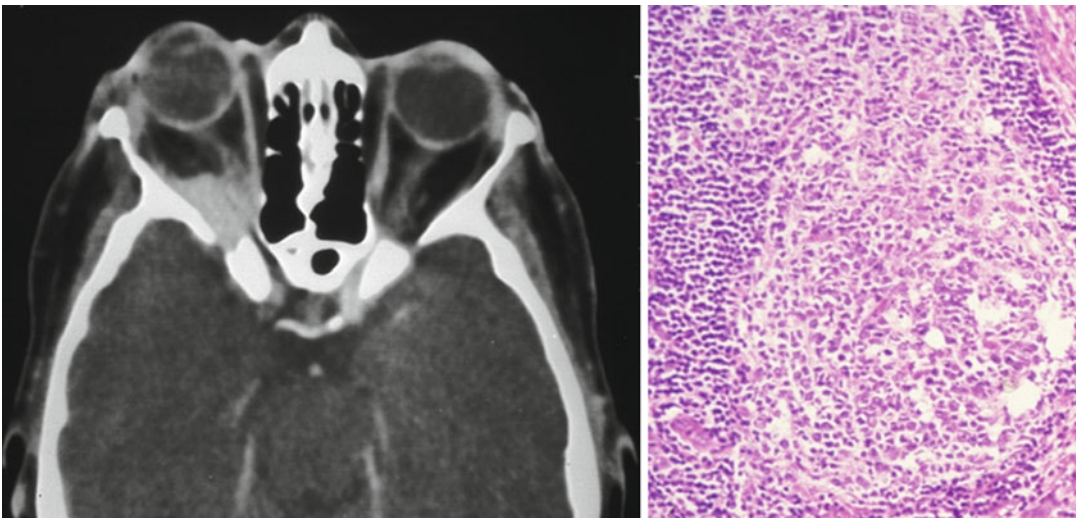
Patient with a right orbital apex syndrome characterized by the sudden development of right-sided orbital pain, injection, conjunctival chemosis, ophthalmoparesis, proptosis, and decreased vision associated with a right relative afferent pupillary defect. *Left*, axial CT scan
